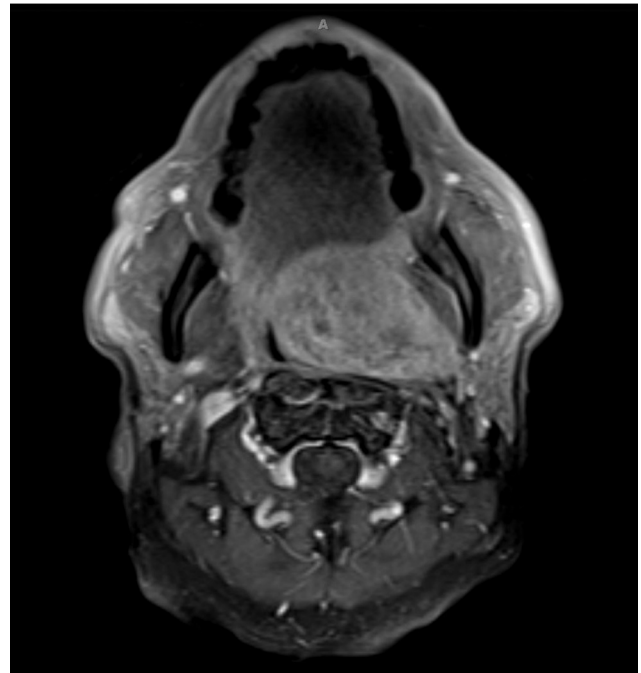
The typical MRI appearance of a deep parotid lobe tumor extending into the prestyloid parapharyngeal space. An axial T1-weighted image showing the tumor is arising from the deep lobe of the parotid gland, as there is no distinguishable fat plane between the parotid and the parapharyngeal space.
